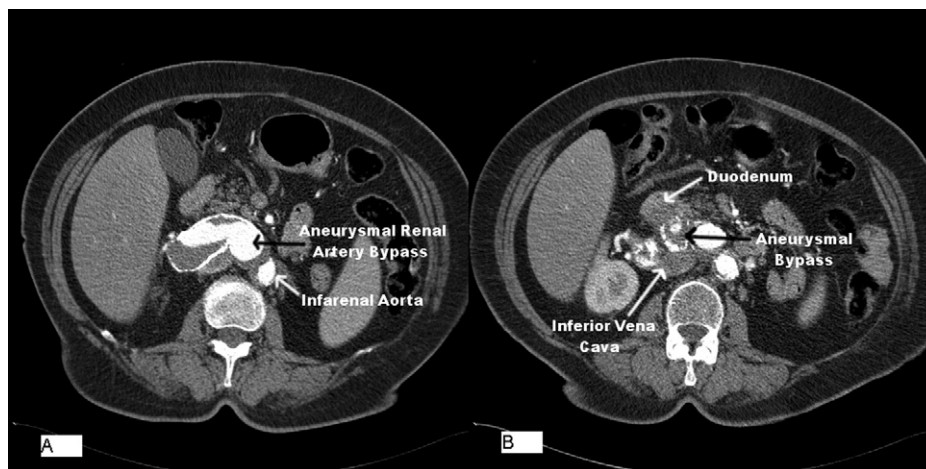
A, Contrast-enhanced computed tomography scan of the abdomen demonstrated aneurysmal degeneration of the aorta-to-right renal bypass immediately caudad to the duodenum; (B) the same scan demonstrated the absence of a distinct tissue plane between the bypass aneurysm and the duodenum.
